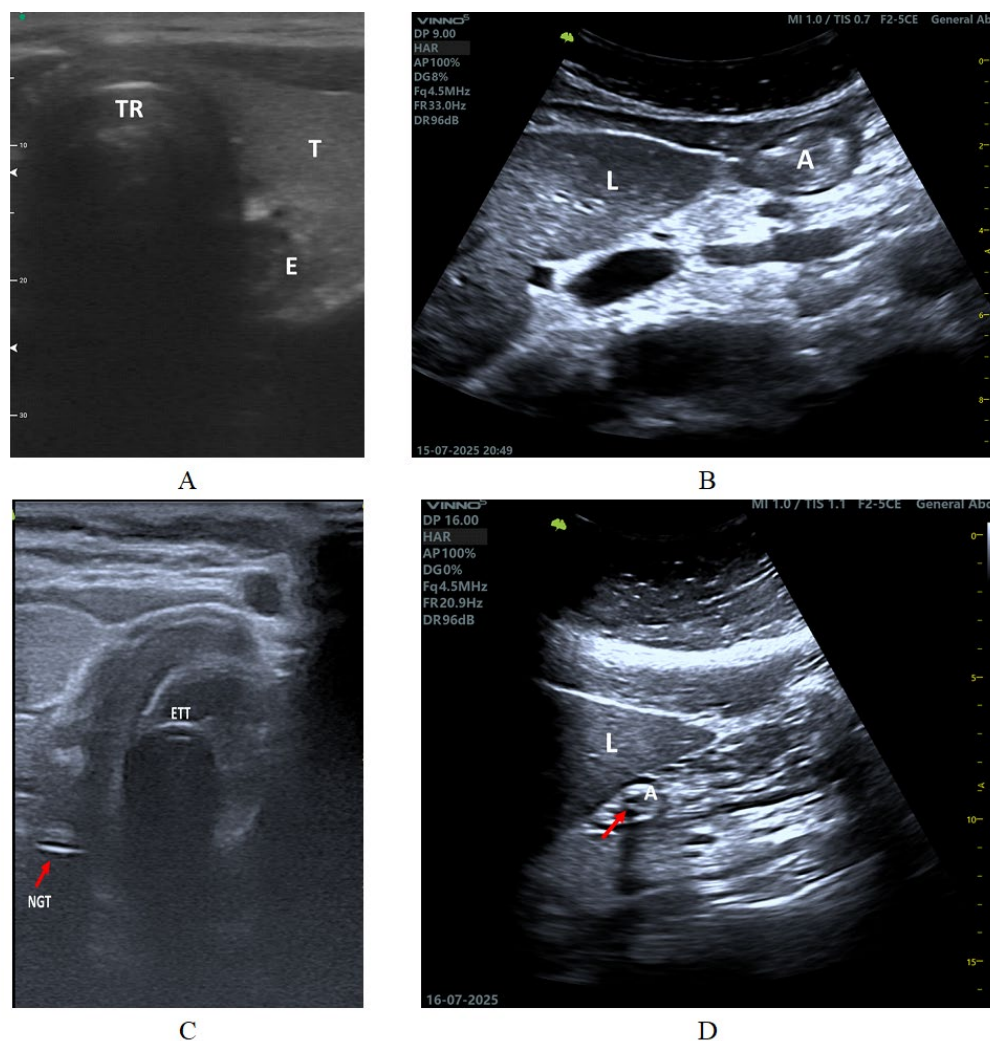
Representative sonoanatomy for NGT placement verification. (a) Transverse ultrasound view of the esophagus (E) adjacent to the trachea (T) and tracheal rings (TR). (b) Longitudinal abdominal ultrasound demonstrating the gastric antrum (A) in relation to the liver (L). (c) Transversal cervical ultrasound showing the nasogastric tube (NGT) in proximity to the endotracheal tube (ETT). (d) Longitudinal abdominal ultrasound demonstrating the gastric antrum (A) adjacent to the liver (L), with an arrow indicating the nasogastric tube within the antrum.
